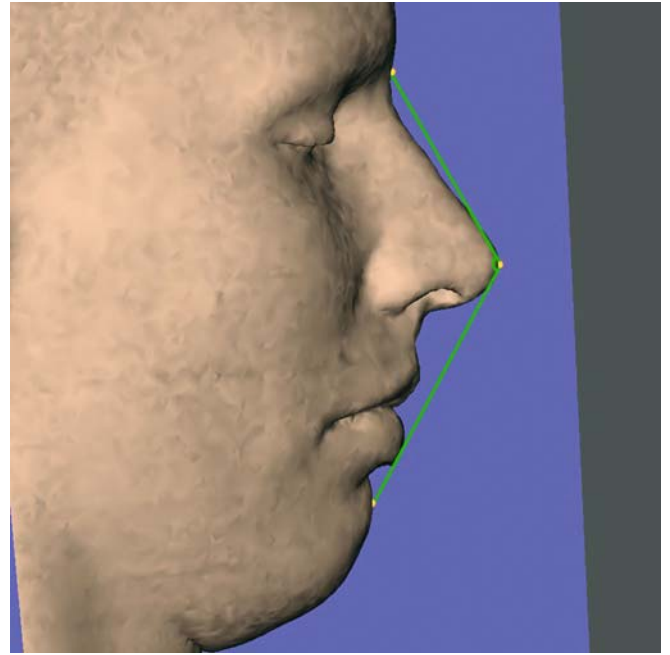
The full soft tissue convexity angle, n-prn-pg, is a projected angular soft tissue measurement on the median (z) 3-D cephalometric reference plane (3-D CT, soft tissues, patient K.C.)
